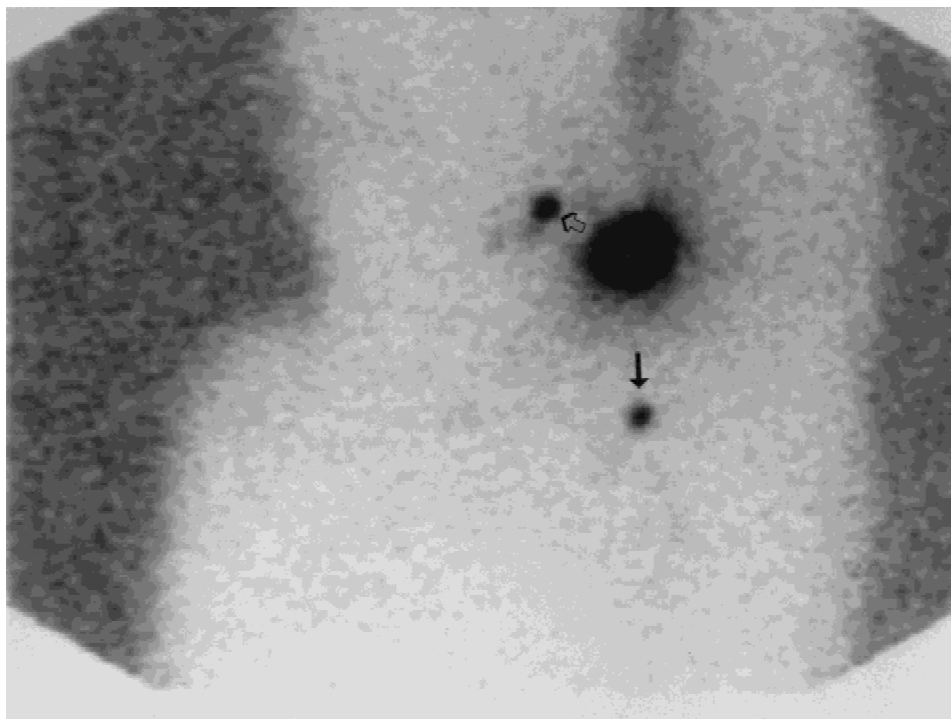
50-year-old white male with an “intermediate thickness” melanoma on the left shoulder. The body outline for anatomical orientation is created with a cobalt fluid source placed behind the patient. Preoperative lymphoscintigraphy with Technetium Sulfur Colloid shows bidirectional drainage to sentinel nodes in both the left neck (open arrow) and left axilla (closed arrow). Both basins are at risk for metastatic disease, while the clinical prediction would be for drainage to just the left neck. Intraoperative lymphatic mapping harvested the SLN in both locations with the neck being negative and the axilla having micrometastatic disease.
